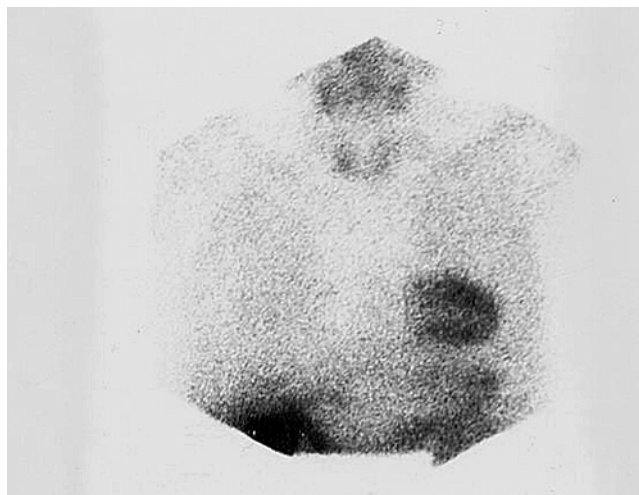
A 53-year-old patient with breast carcinoma and left mastectomy a year ago. Because of pain in her right breast, she had an X-ray mammography with a doubtful result. Scintimammography with ^{99m}Tc -sestamibi followed which was clearly negative. The patient is well 3 years later.
